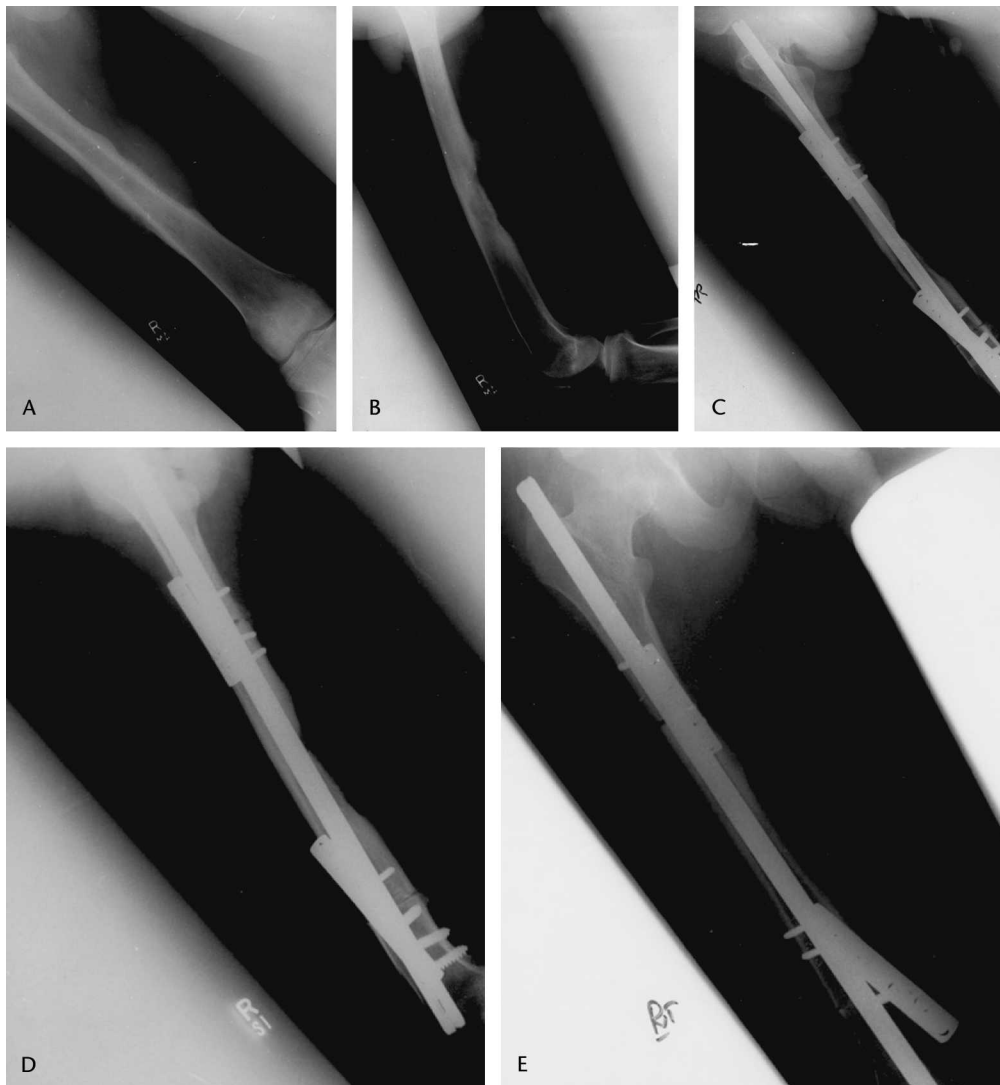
(A) An AP radiograph shows diaphyseal osteogenic sarcoma of the femur in a 21-year-old man. (B) A lateral radiograph of the same patient shows posterior cortical erosion. (C) A postoperative radiograph taken immediately after wide-margin excision is shown. The autoclaved segment was 12 cm long and was stabilized by an IM nail and compression plates. (D) Oblique and (E) AP radiographs taken 1 year postoperatively show how the distal osteotomy site healed with progressive union at the proximal osteotomy site. The proximal osteotomy site also healed after 8 months.
